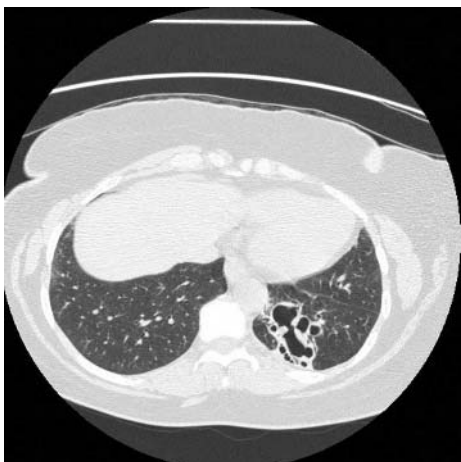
Thoracic CT scan showing cystic changes in the left lower lobe posterior segment.
